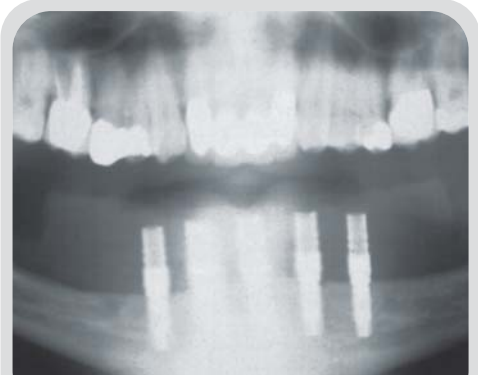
Postoperative radiograph of the mandibular implants on the day of placement and loading.
